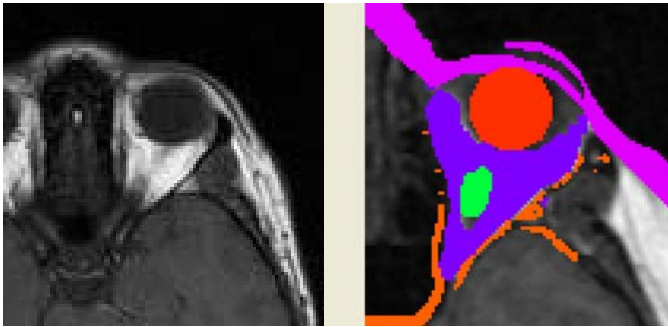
MRI scan (left) and segmentation (right) of the eye.
